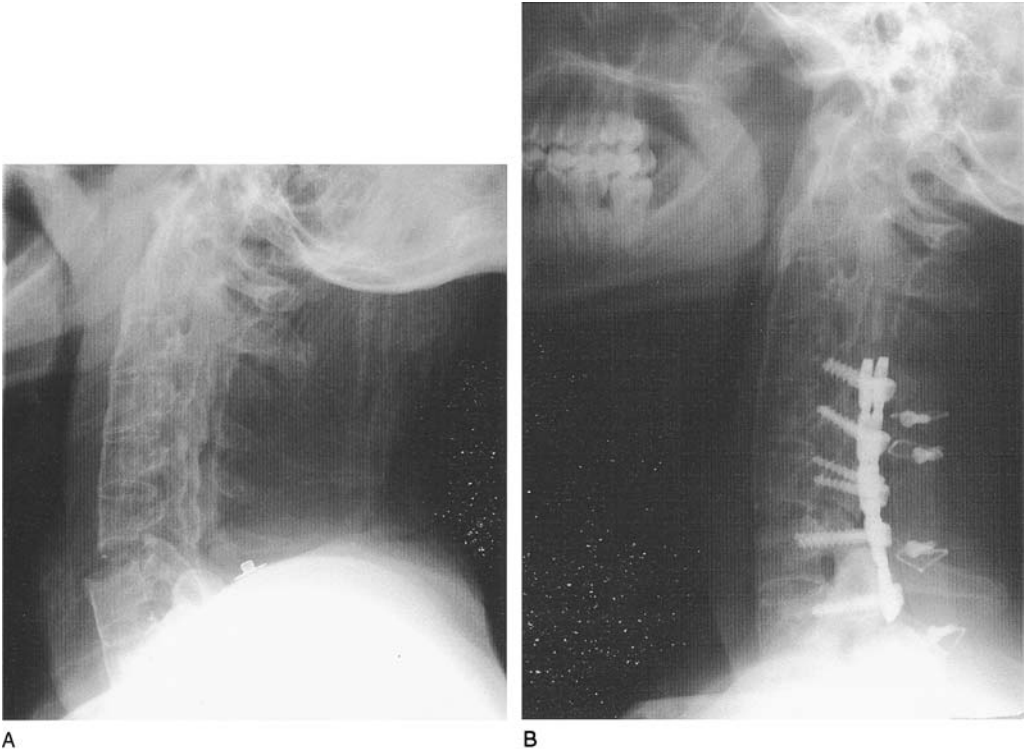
Lateral plain films of a 44-year-old male with ankylosing spondylitis demonstrates (A) C6–7 cervical fracture with obvious anterior vertebral body fusion and (B) cervical stabilization of the C6–7 bodies after fracture stabilization using lateral mass screws and spinous process wires.
